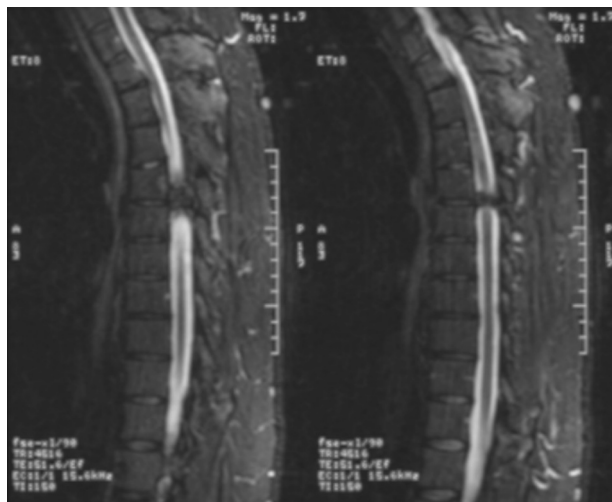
Sagittal T2 magnetic resonance imaging showing cord compression at the T5/T6 level.
